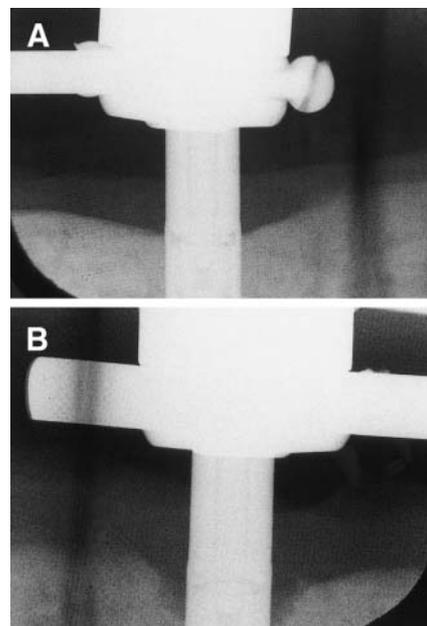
(a) Radiographic view of an IMZ implant without bone loss after 1 year. (b) Radiographic view of an IMZ implant with bone loss after 1 year.
